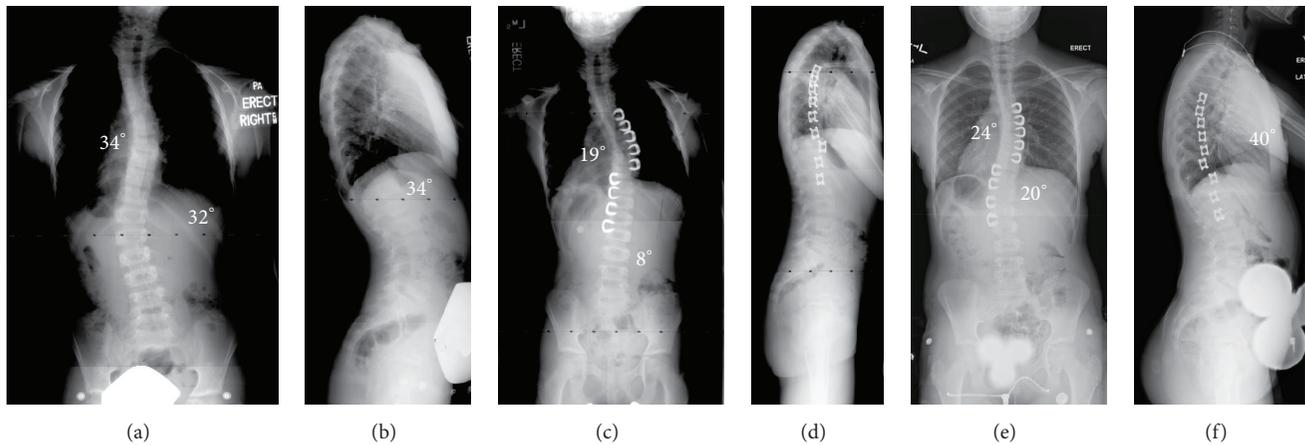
(a and b) This is an 8-year-old girl who presented with a double major curve (right thoracic: 34°, left thoracolumbar: 32°). The lateral X-ray shows a normal sagittal contour, with kyphosis from T5 to T12 of 34°. (c and d) Following VBS, the first erect PA and lateral films show the staples to be intact. There is excellent correction of both curves, with the thoracic curve correcting to 19° and the lumbar to 8°. (e and f) Films from 2-1/2 years postoperatively show successful maintenance of the thoracic curve (now measuring 24°) and the lumbar curve (now measuring 20°). The lateral film from 2 years postoperatively shows a 40° kyphosis from T5 to T12.
